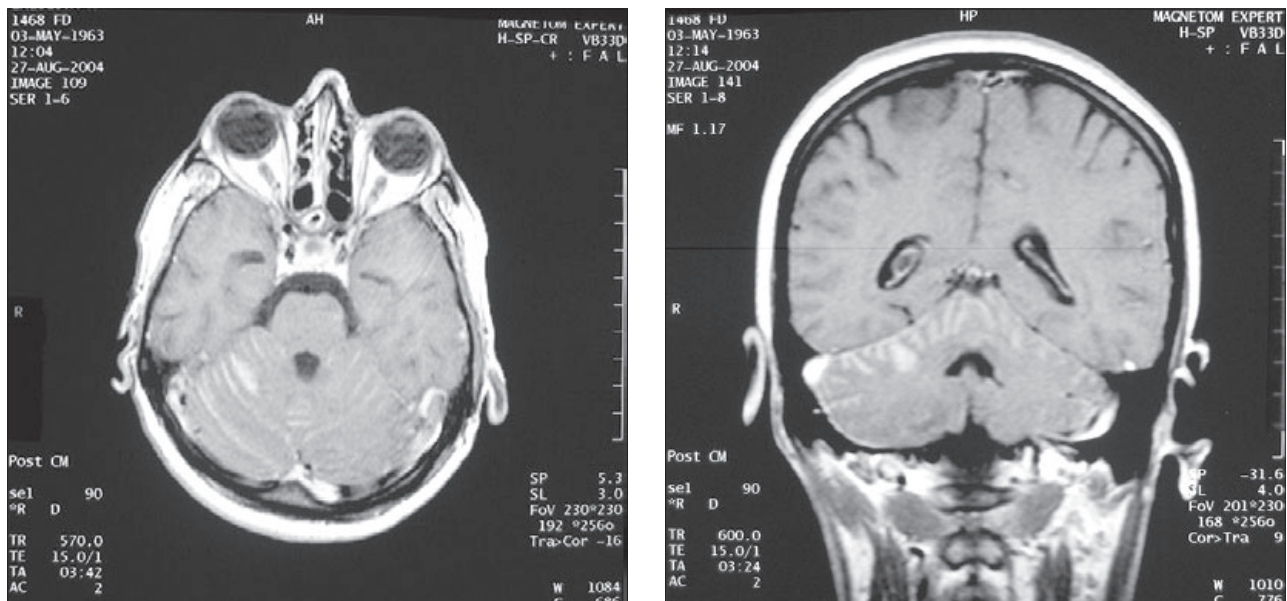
MR images (a – axial, b – coronal) – contrast enhanced T1 weighted MR image showing enhancement along the surface of the cerebellum.
